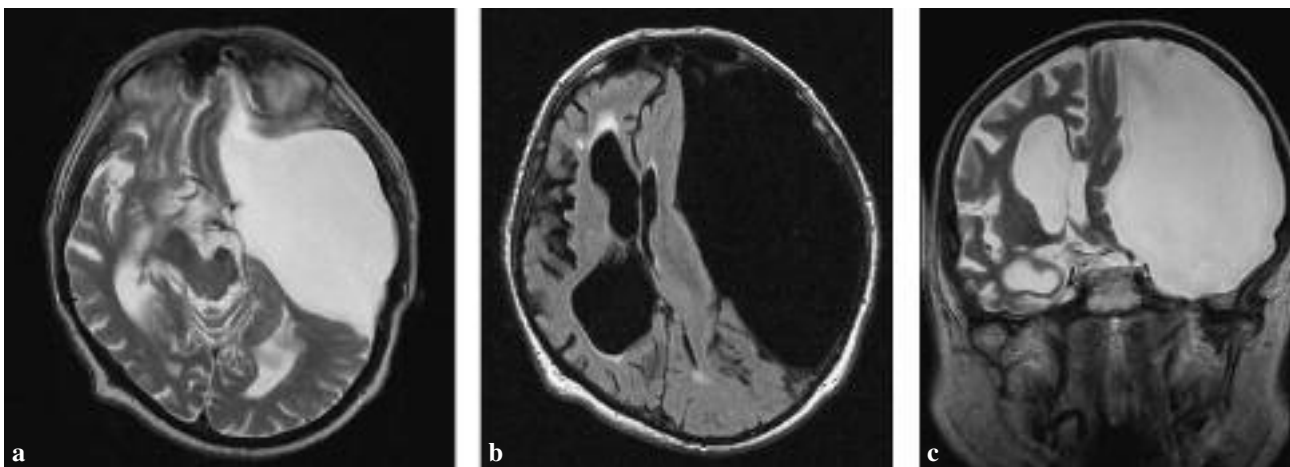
Brain MRI showing the giant subarachnoid cyst (7.4 × 18.2 × 12.8 cm) on the left and overlying skull asymmetry. a) axial T2; b) axial FLAIR and c) coronal T2 sequence.
